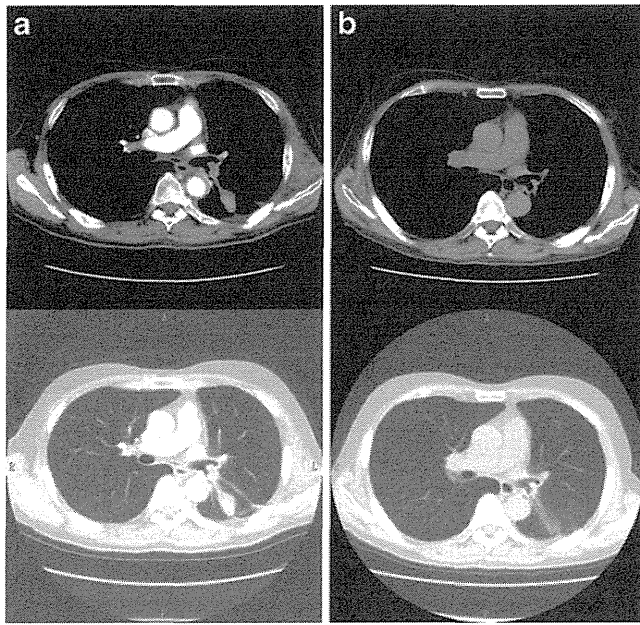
a CT scan performed at diagnosis, shows a 2 cm×3.4 cm mass in inferior lobe of the left lung, and thickened bronchial walls of ipsilateral hilar region. b CT scan performed at admission by pulmonary hemorrhage, shows tumor shrinkage in inferior lobe of the left and improvement of thickened bronchial walls of left hilar region
